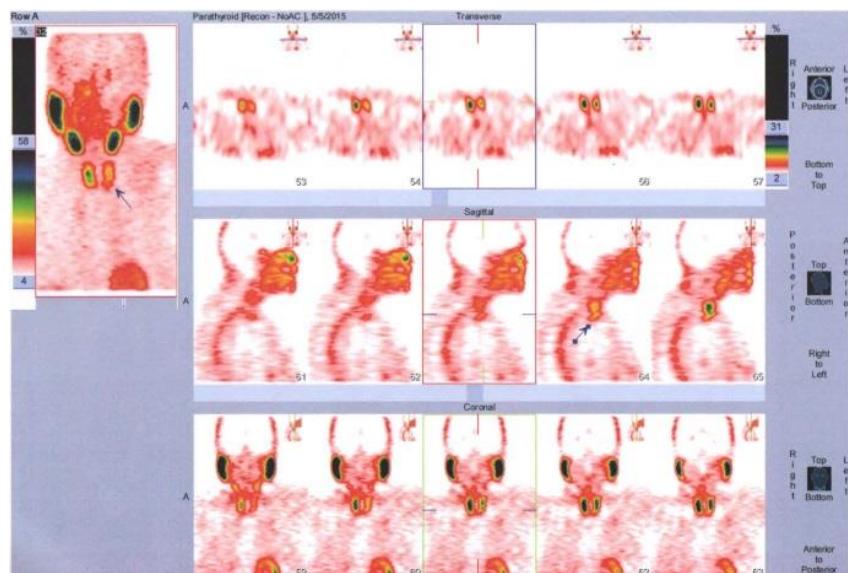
SPECT images show an area of hyperfixation, located dorsally and caudally of the left thyroid lobe, suspicious for a parathyroid adenoma.
